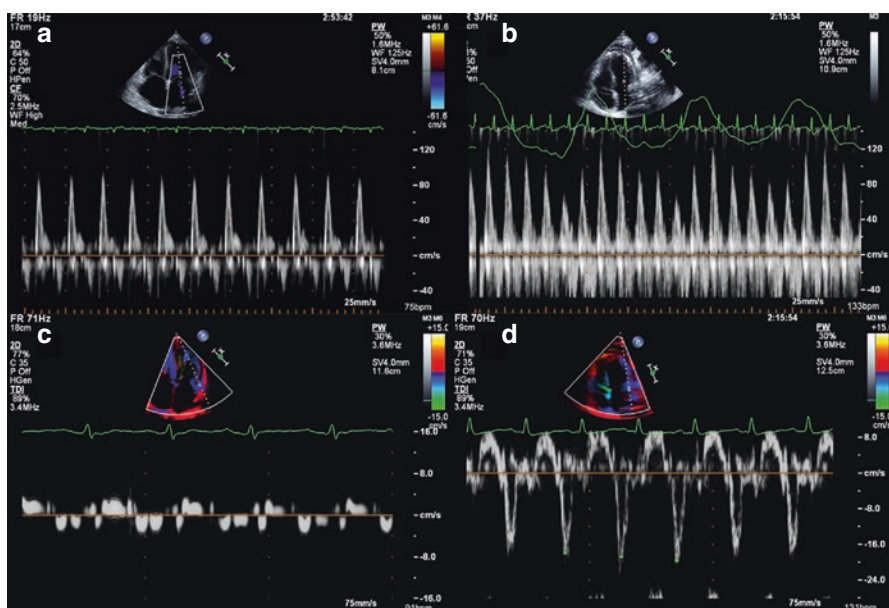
Differences in pericardial constriction compared to restrictive cardiomyopathy. Pulsed Doppler recordings of LV inflow (a, b) and tissue Doppler myocardial velocities of the basal lateral wall (c, d) in a patient with restrictive cardiomyopathy (a, c) and constrictive pericarditis (b, d). Reproduced with permission from [14]
